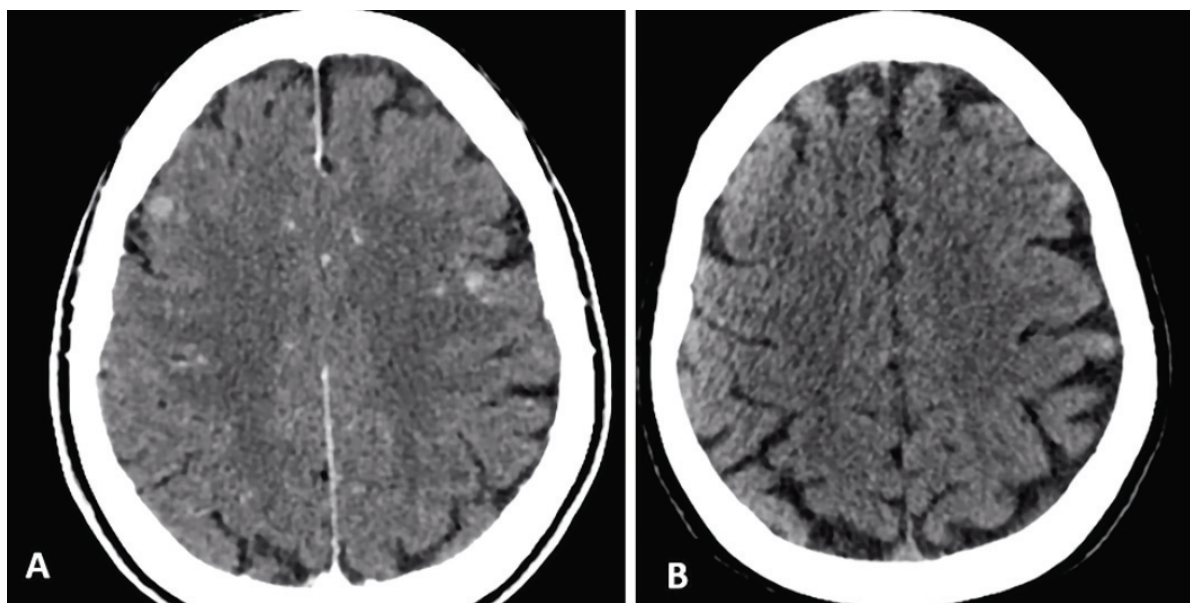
A: A brain CT scan of case 3 performed in October 2017 confirmed multiple parenchymal lesions. B: Brain CT scan performed in June 2018 with evidence of intracranial complete response. CT scan – computed tomography scan.
